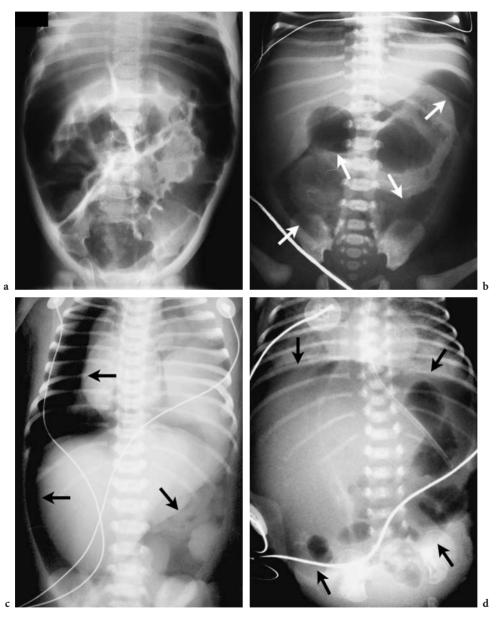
Pneumoperitoneum. a Massive pneumoperitoneum complicating the insertion of a rectal tube. b Pneumoperitoneum (*arrows*) in a newborn with ileal atresia. c Massive pneumothorax, pneumomediastinum and pneumoperitoneum (*arrows*) in a patient that had been supported by mechanical ventilation. d Neonate with abdominal distension following the insertion of a rectal thermometer. A supine radiograph shows a lucency occupying the entire abdominal cavity (*arrows*) and the falciform ligament outlined by air
